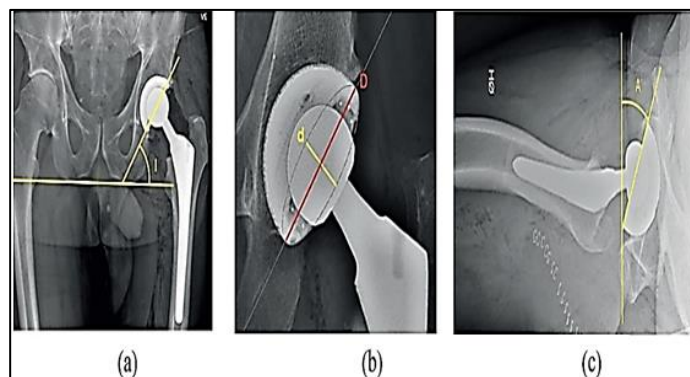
(a) Radiographic cup inclination (b) Radiographic cup anteversion (c) Radiographic cup anteversion from a lateral shoot through radiograph
